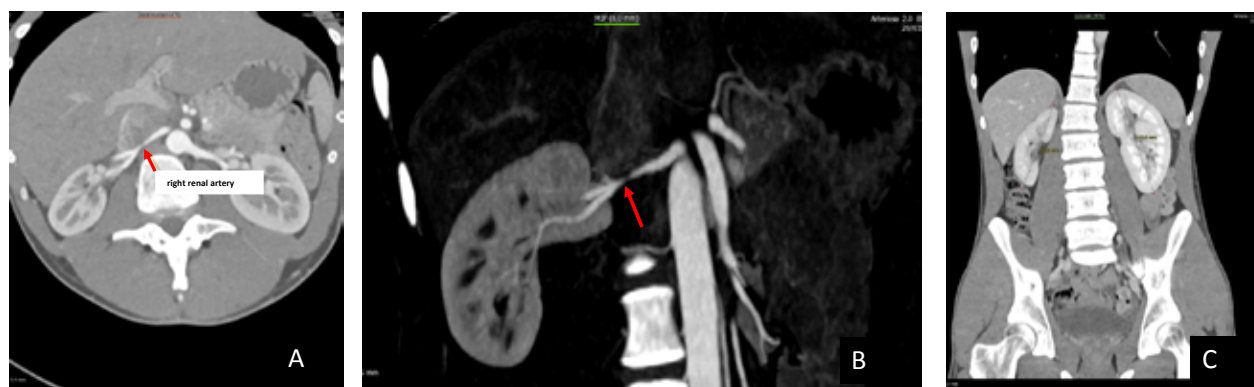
Upper abdominal CT Scan with contrast injection (A) and Magnetic Resonance Imaging (B) showing a narrowing of medium-distal portion of the right renal artery and (C) kidneys asymmetry.
